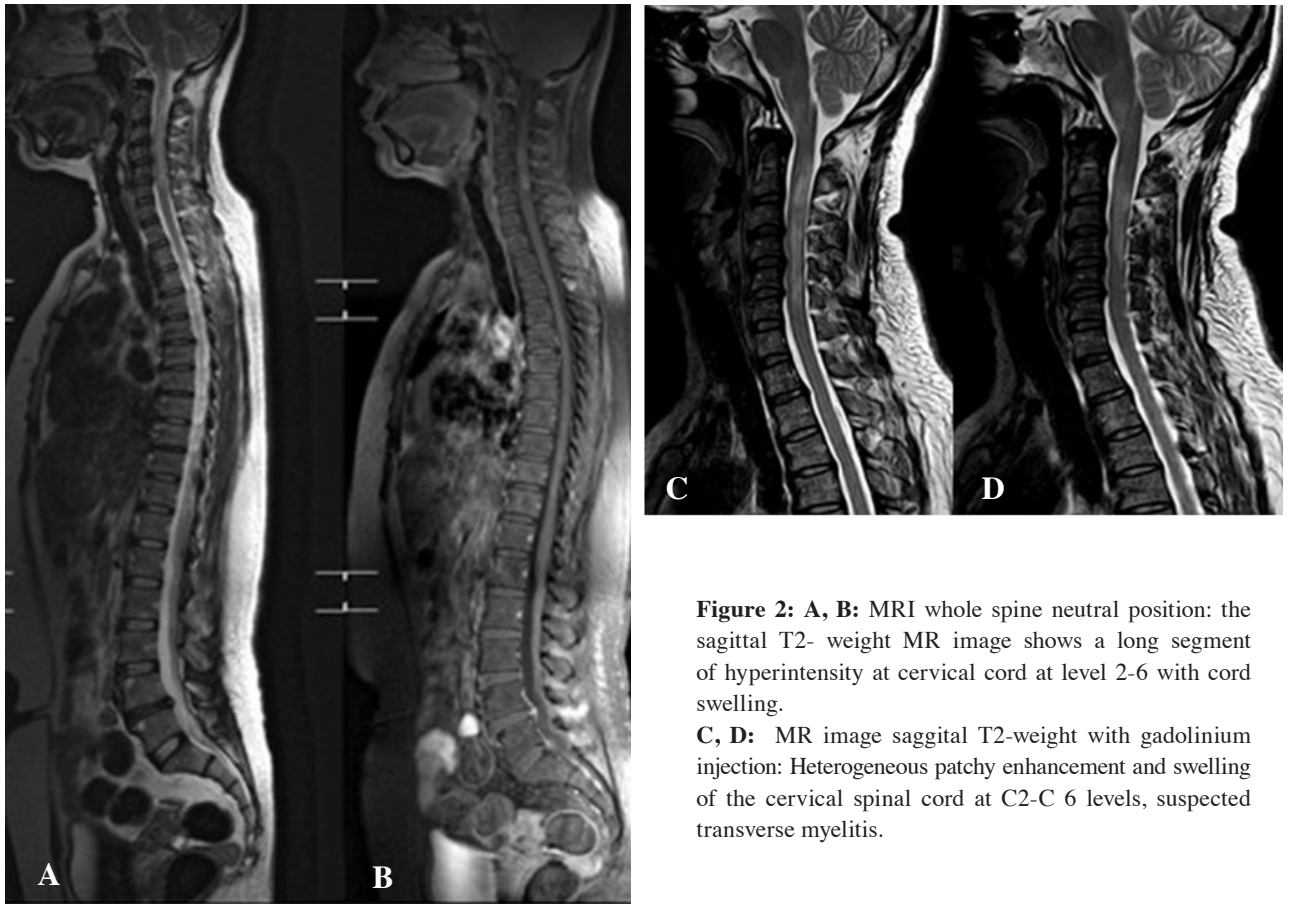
A, B: MRI whole spine neutral position: the sagittal T2- weight MR image shows a long segment of hyperintensity at cervical cord at level 2-6 with cord swelling.
